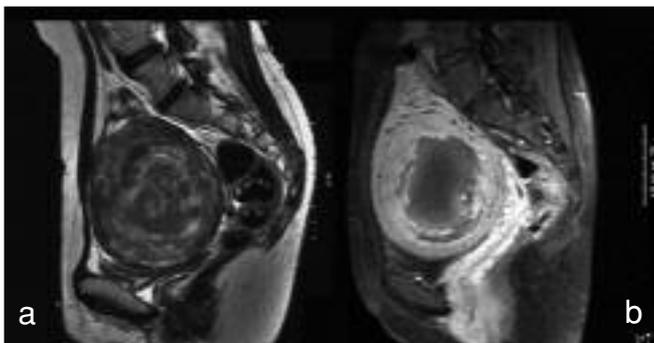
MRI images of Patient 1 before and after operation. a) An intramural node 7 cm in size can be seen in the sagittal T2-weighted image 1 cm left from the midline before operation. b) In the fat saturated enhanced T1-weighted image 7 days after operation, most of the node is avascular.
